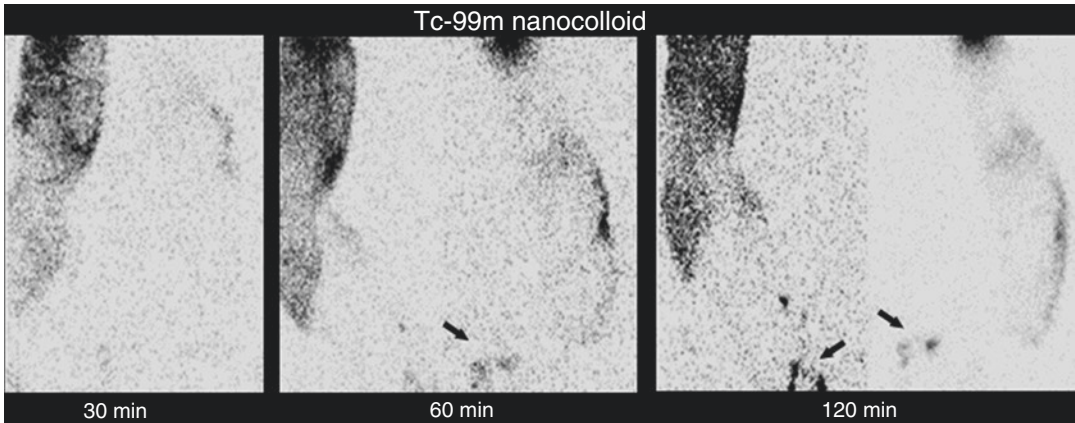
Lymphoscintigraphy of the upper extremities for a 75-year-old woman with history of long-standing lymphedema in upper limbs. There is dermal backflow which is significant in the right arm and mild in the left
